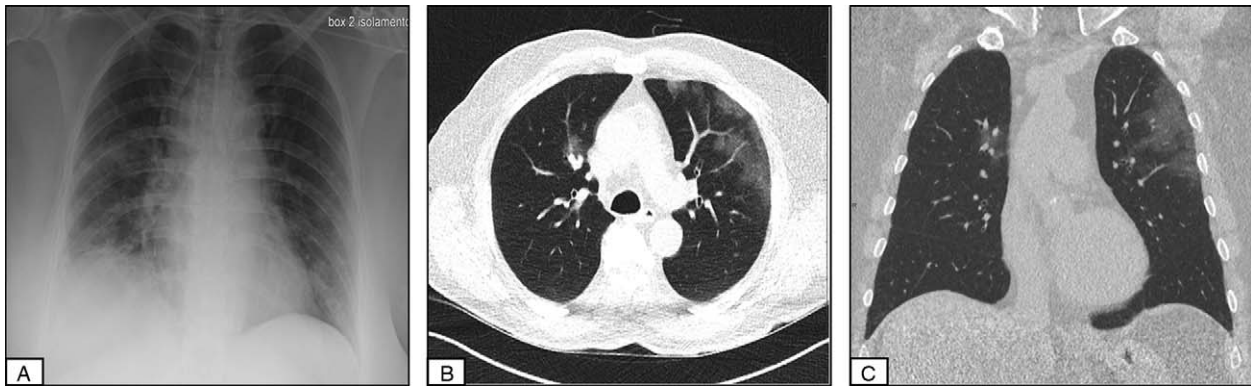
Patient 3: lung infiltrates on chest X-ray and chest ultra-low dose CT. Chest X-ray showed ill-defined infiltrates on the right mid and basal fields (A). Ultra-low dose CT showed diffuse bilateral infiltrates (B and C).
